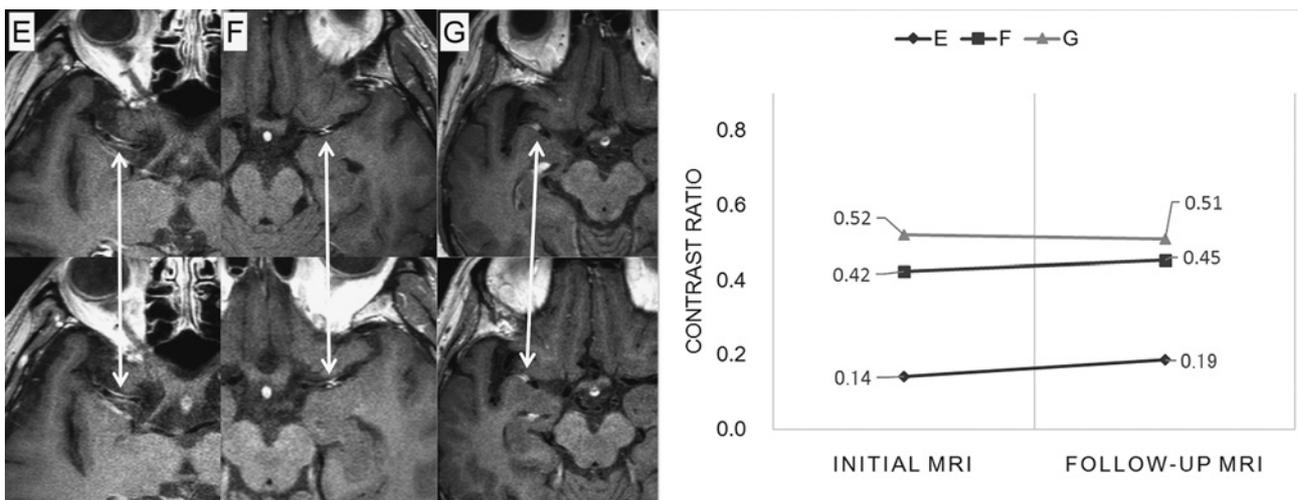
Contrast-enhanced MR images at the initial stage and follow-up stage are shown for 3 patients, as in Figure 3. Arrows indicate focal enhancement at the M1 segment of the middle cerebral artery (MCA) stenotic region. Graphs on the right are the contrast ratios at the initial and follow-up stages. Focal enhancements are not reduced.
